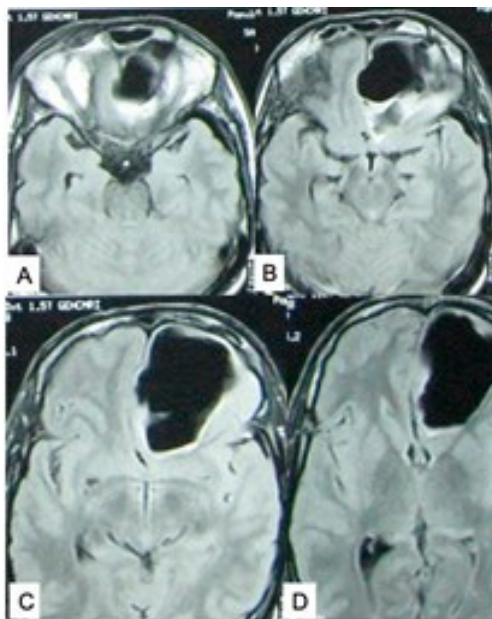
(A–D) MRI of the brain (axial FLAIR images) showing frontal tension pneumocephalus in a spontaneous CSF fistula (through left frontal sinus) case. Source: Figure by authors.
